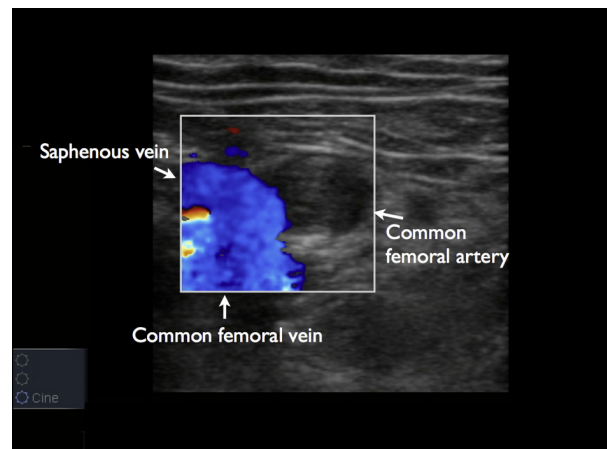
Transverse color flow Doppler ultrasound image of the left common femoral artery and saphenous common femoral vein junction. Flow can be seen in the common femoral and saphenous veins but arterial flow is absent.
